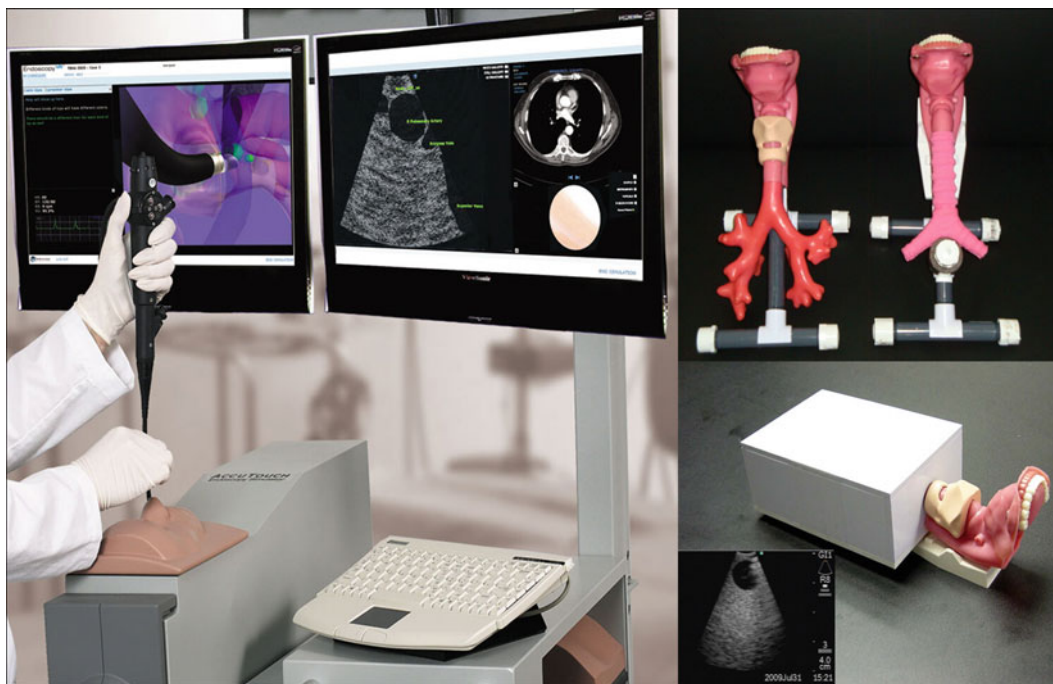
Examples of hi-fidelity and lo-fidelity models for teaching bronchoscopic inspection, conventional transbronchial needle aspiration, and endobronchial ultrasound (Courtesy of Dr. Henri G. Colt, M.D.)
